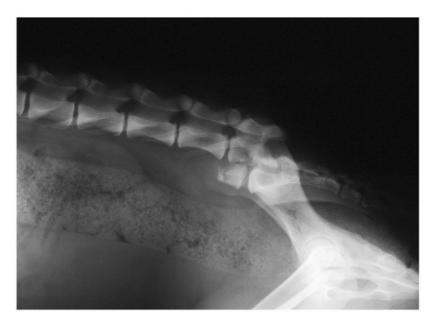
Post-trauma lateral radiographic projection of the seventh lumbar vertebra fracture showing cranio-ventral displacement of the sacrum.
